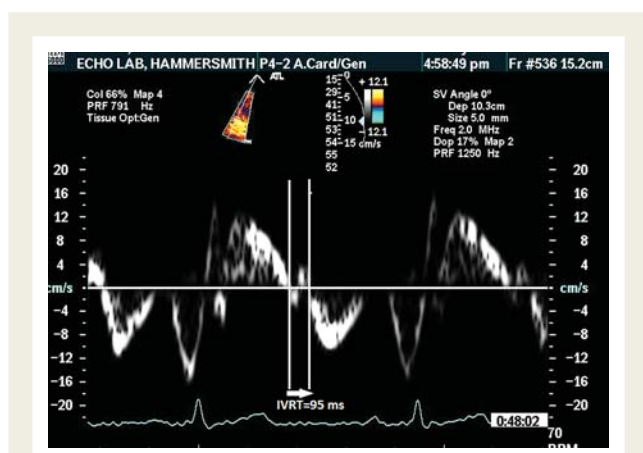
Intervals measured from pulsed tissue Doppler obtained from the lateral tricuspid annulus. ICTt, tissue isovolumic contraction time; ETt, tissue ejection time; IVRTt, tissue isovolumic relaxation time.
